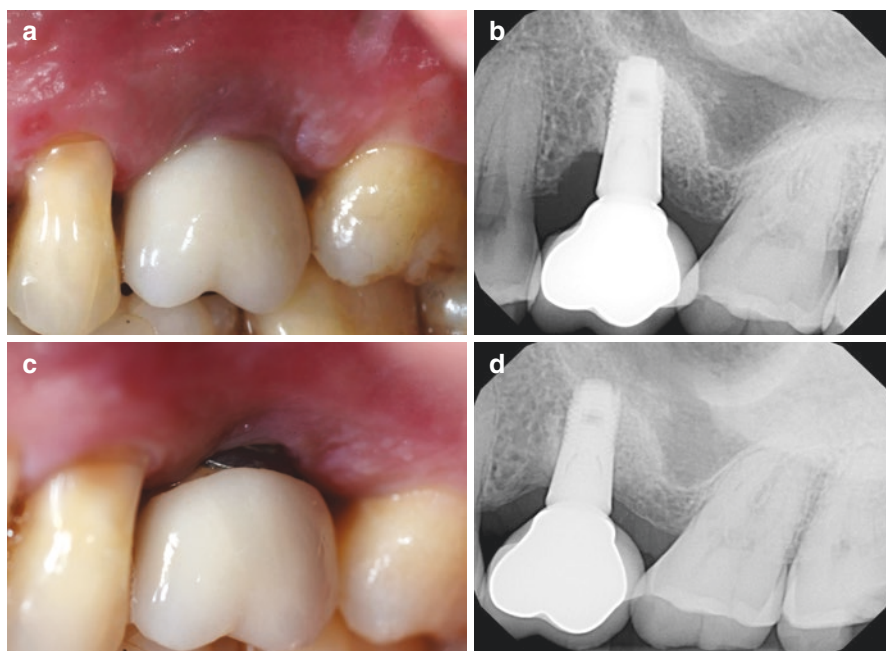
Clinical application of digitally pulsed Nd:YAG laser in periimplantitis treatment in posterior. The patient was 47-year-old male who was seen for discomfort and suppuration on the upper left first molar (a). Probing showed non-maintainable pockets. The X-ray showed vertical bone loss on upper left first molar (b). LAPIP treatment was performed on the same day as Fig. 5.4a, b. No removal of restoration was necessary, and he was kept on a 3-month periodontal maintenance. Once inflammation and swelling of the gingiva resolved, a buccal overhang of the restoration was noted, which probably contributed to the periimplantitis (c). The 44-month follow-up showed decrease in pockets to maintainable levels with no suppuration or BOP. The X-ray showed stable regeneration of bone (d)
